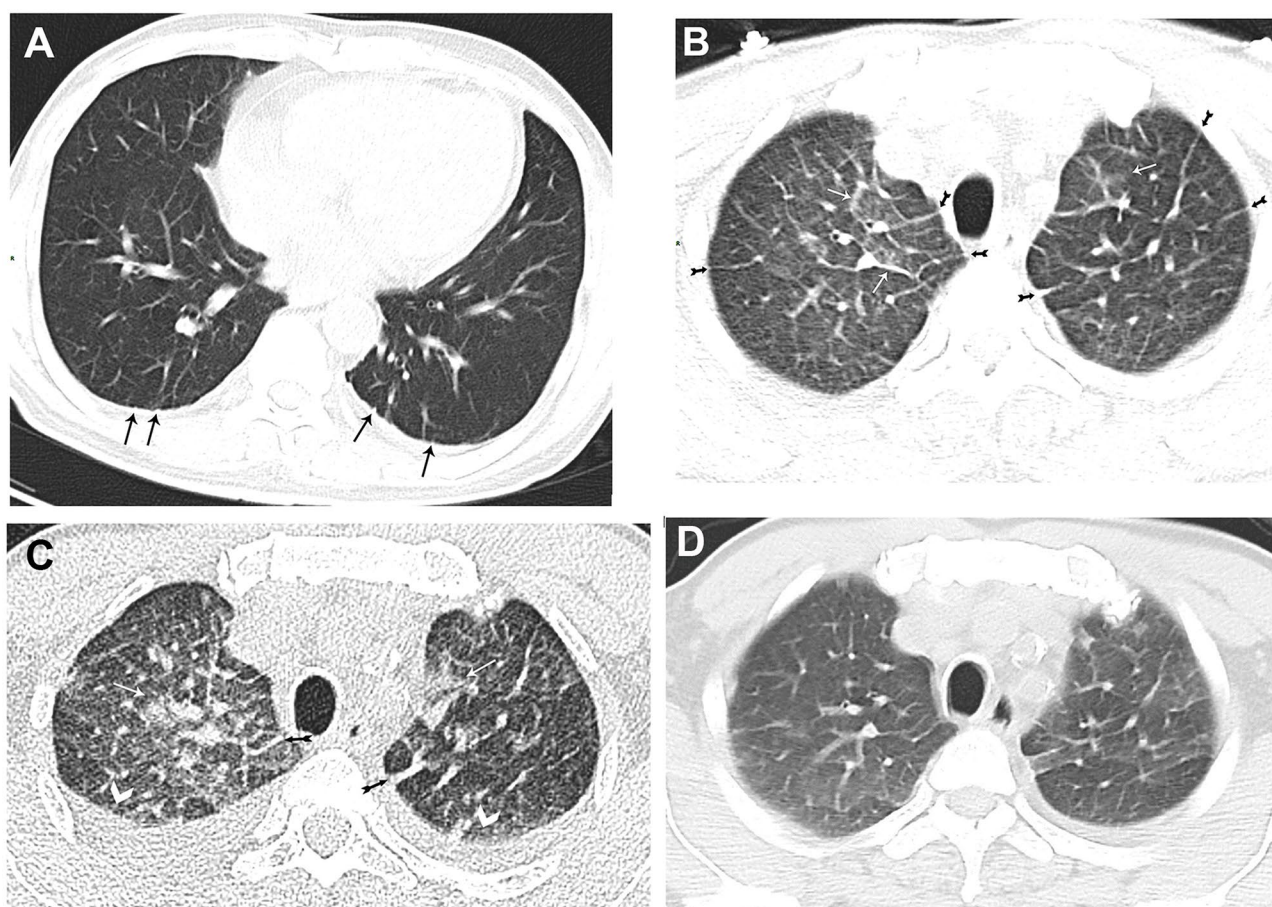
Plain CT examination obtained in a man with positive blood culture for *Burkholderia pseudomallei*. Slice thickness of 5 mm (A, B); Slice thickness of 0.75 mm (C). (A) A small amount of pleural effusion on both sides. The pleural surface is rough, with a small amount of subpleural micronodules and peribronchovascular interstitium thickening visible (arrow). (B) 2 days later reexamination, bilateral intrapulmonary GGO was observed, with lobular GGO in the bilateral upper lobe (white arrow) and thickening of the interlobular septum of both lungs (fish tailed arrow). (C) Reexamination in 3 days with thin-section images showed increased pleural effusion on both sides (arrowhead), thickening of interlobular septa (fish tailed arrow), and expansion of ground-glass opacities (white arrow). (D) The pulmonary lesions were obviously absorbed after 13 days of treatment
